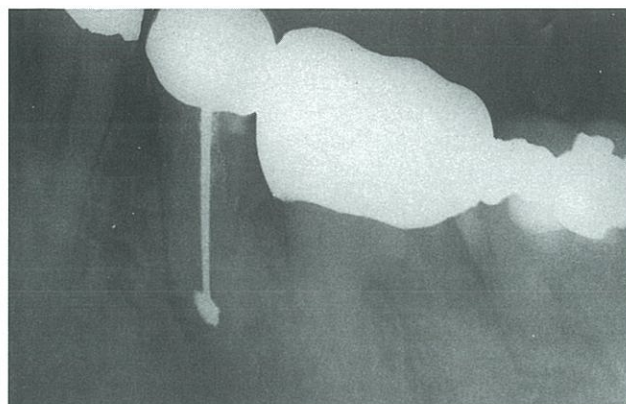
Case 3, immediate postoperative radiograph. Note that the periapical area is continuous with the interproximal defect between teeth nos. 20 and 21. Also note the lack of lamina dura at the apex of tooth no. 20 and at the interproximal marginal crest between teeth nos. 20 and 21.
